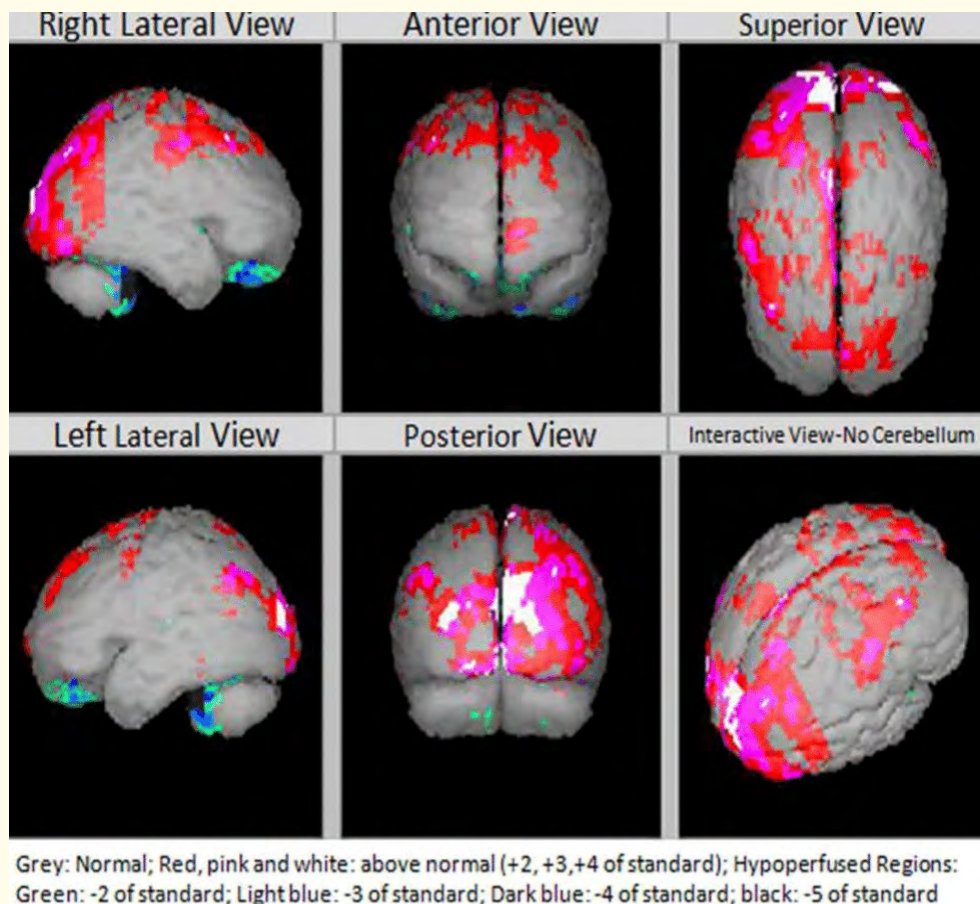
SPECT Scan of the same Parkinson's disease Patient after Therapy Showing Improved Perfusion.
